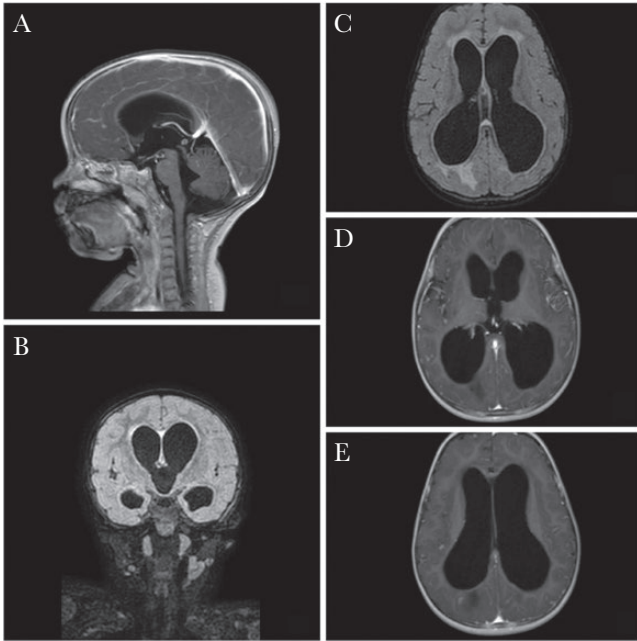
Magnetic resonance image of a 14-month-old child with postmeningitic hydrocephalus. A, Sagittal gadolinium-enhanced T1 images showing communicated, enlarged lateral third and fourth ventricles. B, Coronal fluid-attenuated inversion recovery (FLAIR) images showing enlargement of third and lateral ventricles. C, Axial FLAIR images showing enlargement of lateral ventricles with periventricular hypersignal. D, Axial gadolinium-enhanced T1 images showing leptomeningeal enhancement. E, Axial gadolinium-enhanced T1 images showing enlargement of lateral ventricles.
